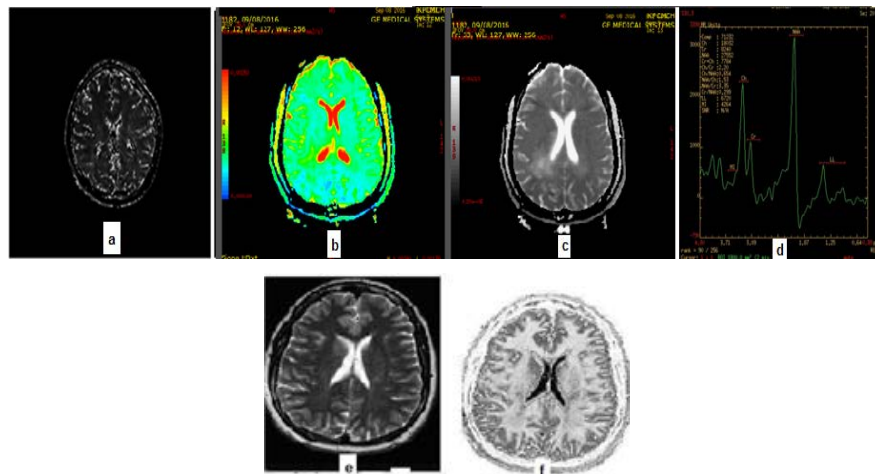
T2 Mapping b. ADC Mapping c. DWI image d. MRS showing quantification of metabolites
